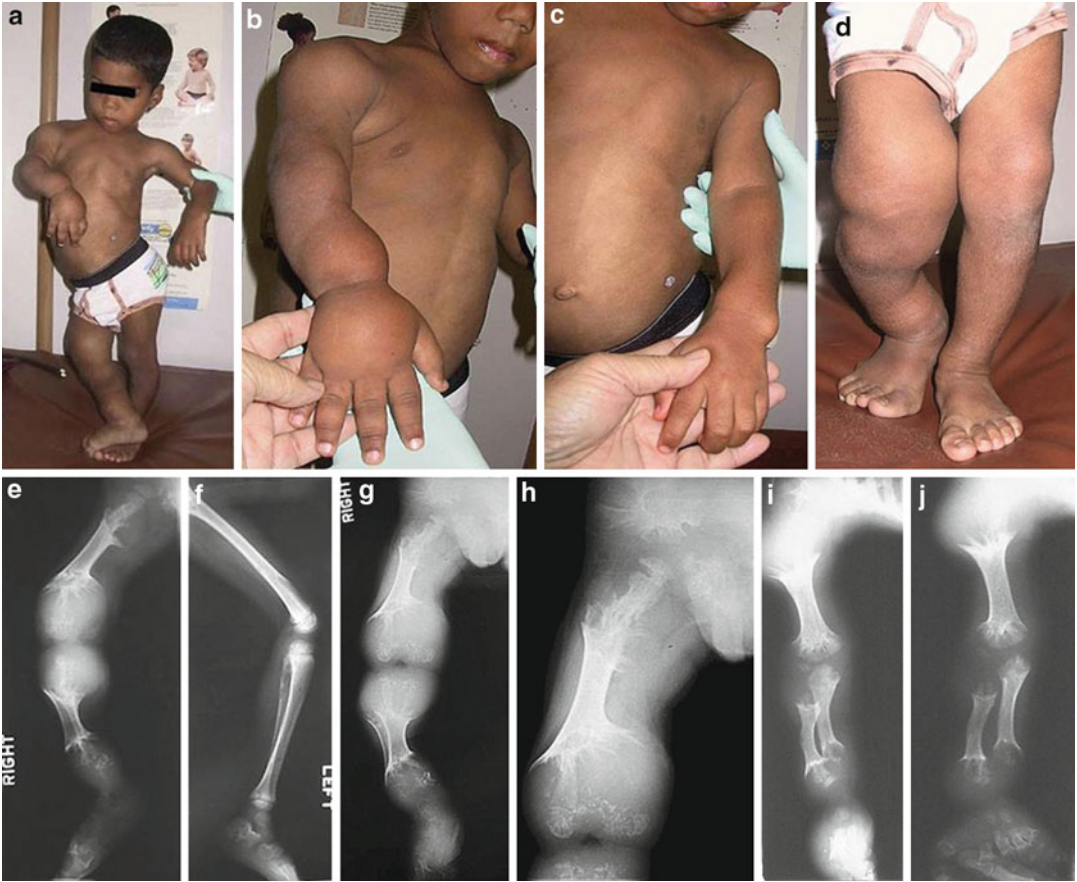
(a–j) A 4-year-old boy with Ollier syndrome showing short stature, scoliosis, and severe limb deformities (a). The *right* limb (b, d) was affected by larger lesions with more prominent limb shortening. Marked swellings were evident on the *right* wrist and fingers. The *left* hand (c) showed Madelung deformity. The radiographs (e–j)
